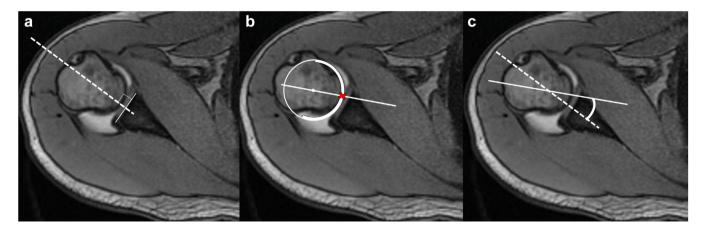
The rotational angle of cine-MRI. The glenoid axis (dotted line) is defined as the line perpendicular to the surface of the glenoid fossa at its midpoint (a). The humeral head axis (white line) is defined as the line connecting the midpoint of the articular surface (red ×) to the *Center* of the humeral head (white dot), which is the *Center* of the best-fit circle (white circle) applied to the humeral head (b). The articular surface is identified using the articular cartilage (bold white line). The rotational angle is defined as the angle between the axes of the glenoid and humeral head (c). *MRI*, magnetic resonance imaging.
